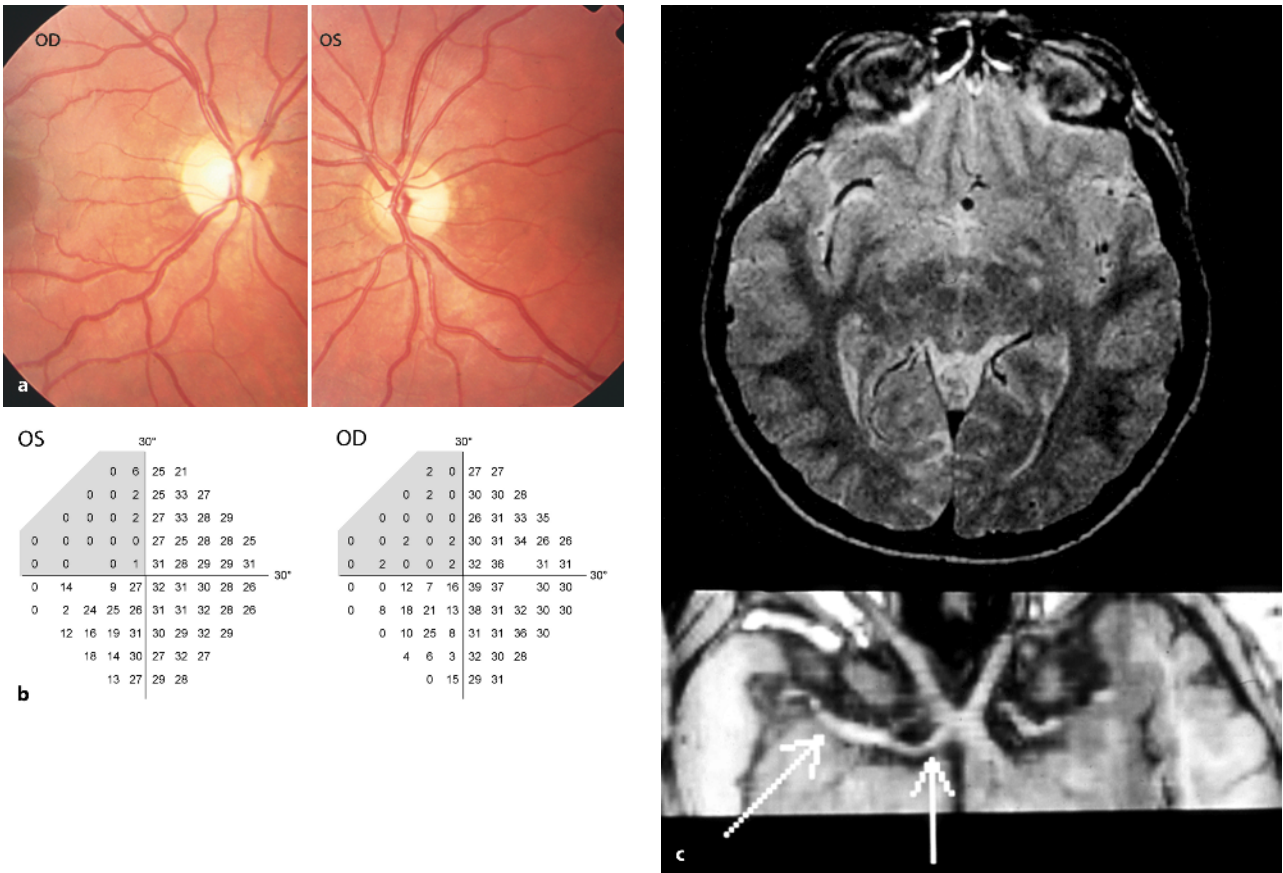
a Lesion of the right optic tract with an incongruous, homonymous quadrantic hemianopia to the left. Optic discs: The disc of the right eye has temporal pallor with a shallow excavation, while the disc of the left eye has a bow-tie pattern of pallor, evident in both the nasal and temporal disc quadrants. This finding is easily missed, when a direct ophthalmoscope is not used. b Visual field testing (static perimetry with the Humphrey Field Analyzer), of the central visual field, i.e., within 30° of eccentricity. c MRI. Shown
